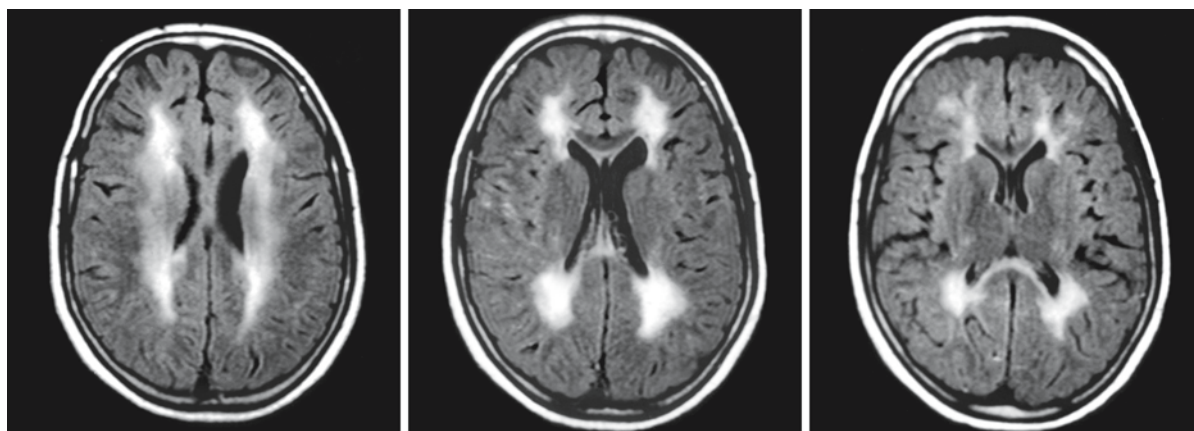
A 13-year-old girl has a history of complicated migraines, but no abnormalities at neurological examination. She has a DNA-confirmed diagnosis of VWM. These FLAIR images show abnormalities in the periventricular and deep white
